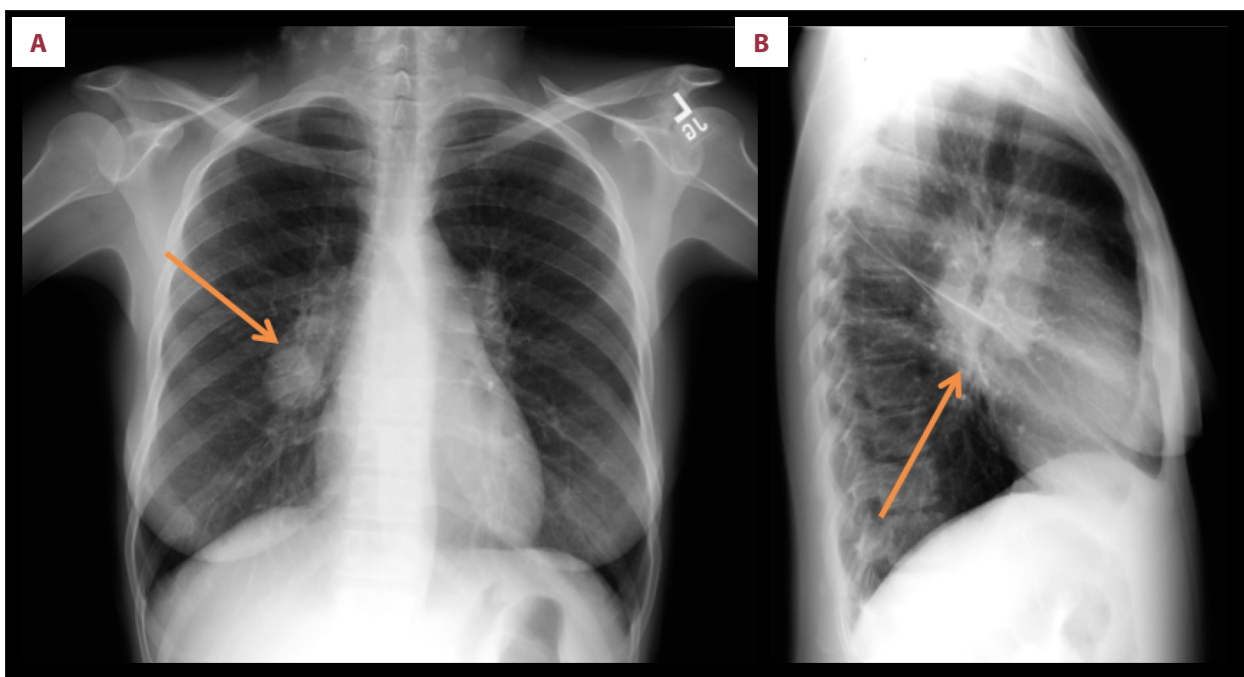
Chest X-ray at presentation: (A) Frontal view, right hilar (arrow) opacities suggestive of lymphadenopathy; (B) Lateral view, subcarinal (arrow) opacities suggestive of lymphadenopathy.
